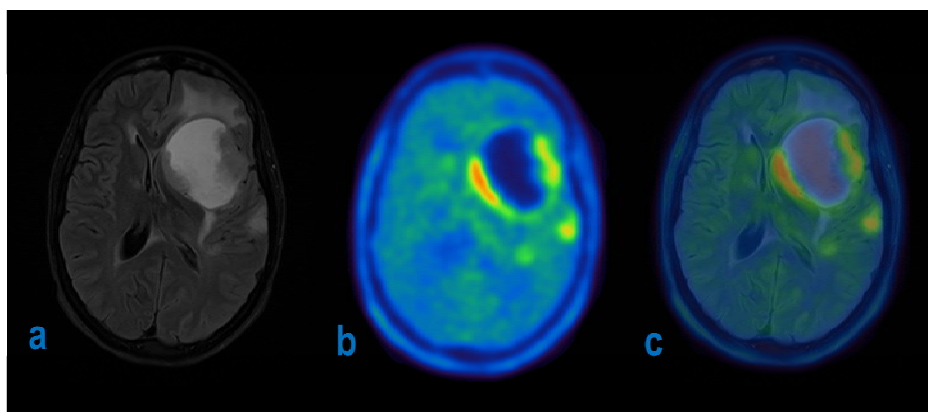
[ $^{18}\text{F}$ ]FET PET/MRI of a patient with recurrent glioma: Data acquisition was performed for 10 min time starting at 30 min post injection of  $\sim 200$  MBq [ $^{18}\text{F}$ ]FET on a Siemens Biograph mMR at the Division of Nuclear Medicine, Vienna General Hospital. (a) T2-weighted MRI image (dark-fluid, TIRM sequence), (b) PET image, (c) fused PET/MRI image combining complementary information of both imaging modalities (Figure provided by Dipl.-Ing. Ivo Rausch, PhD, Center for Medical Physics and Biomedical Engineering, Medical University of Vienna, Austria).
